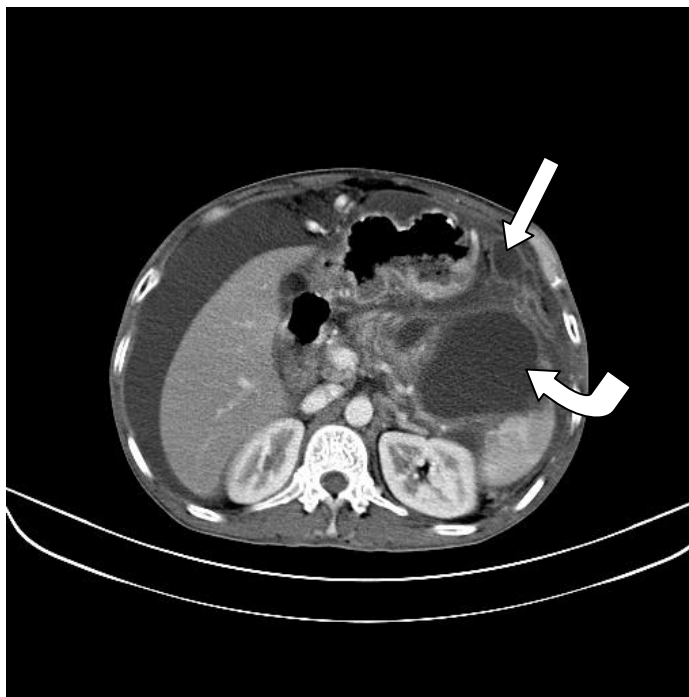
FIGURE # 7 : CONTRAST ENHANCED CT ABDOMEN AXIAL SECTIONS OF ARTERIAL PHASE SHOWING MULTILOCULATED COLLECTION IN RELATION TO PANCREATIC HEAD (ARROW).
